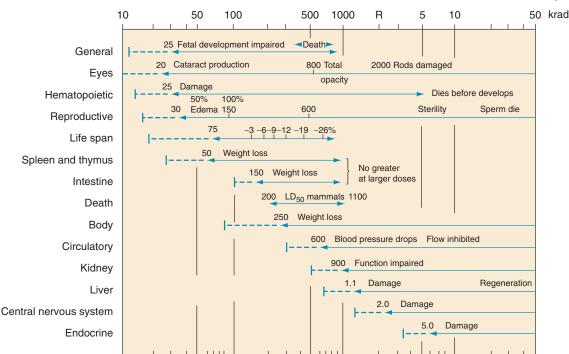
Organ and tissue sensitivity in mammals. The dose values are for whole-body, acute, x-ray, or gamma ray exposures. For lowintensity or fractionated exposure, the lines would be moved toward the right (higher doses). Radiosensitivity is directly related to the proliferative rate of the cells of the organs. (Redrawn from Auerbach PS, Gehr EC: Management of Wilderness and Environmental Emergencies. New York, Macmillan, 1983.)
